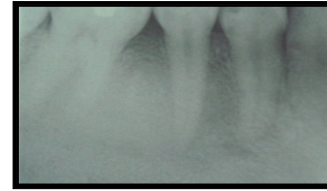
Periapical radiograph showing a diffuse "ground glass" radiographic appearance
